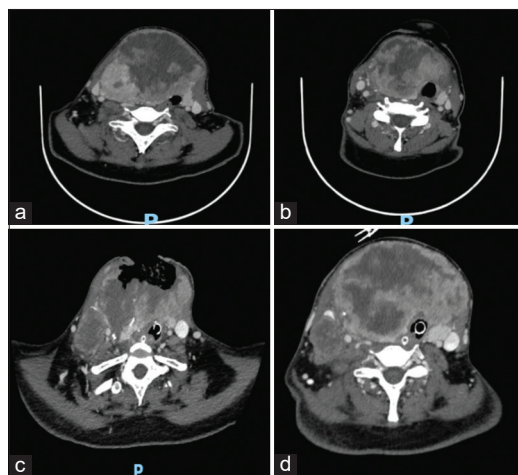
Contrast-enhanced computed tomography neck of the patient preoperatively (a and b) and postoperatively (c and d)
